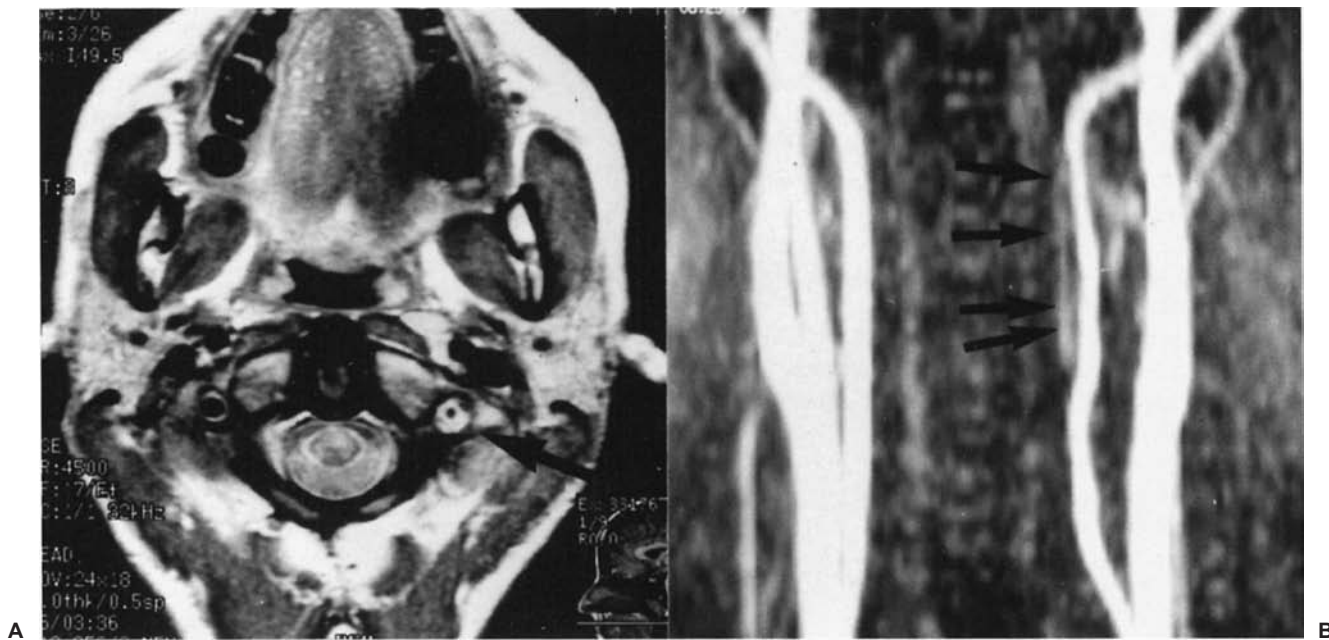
Left extracranial vertebral artery dissection. A: Axial T2-weighted imaging of the brain demonstrating a hyperintense signal of the left vertebral artery corresponding to the mural hematoma (arrow) surrounding the residual lumen. B: Magnetic resonance angiography showing a signal corresponding to the mural hematoma (arrows) with increased external diameter consistent with a dissection.
